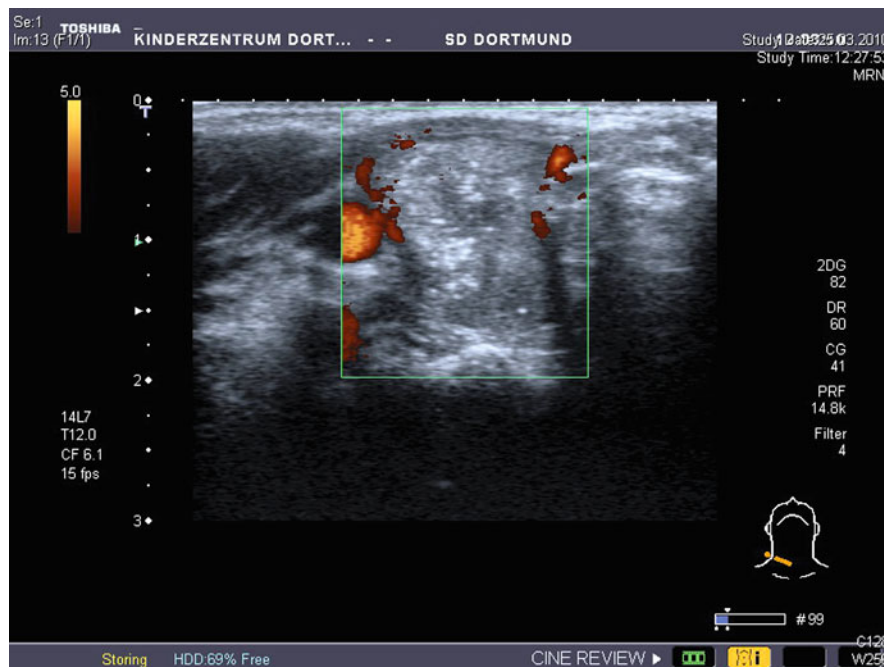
Ultrasound of a thyroid carcinoma in right lobe of the thyroid
